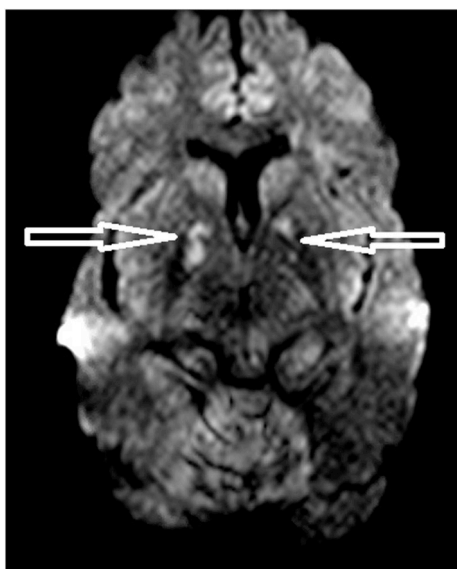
MRI brain showing bilateral globus pallidus ischemic injuries.
